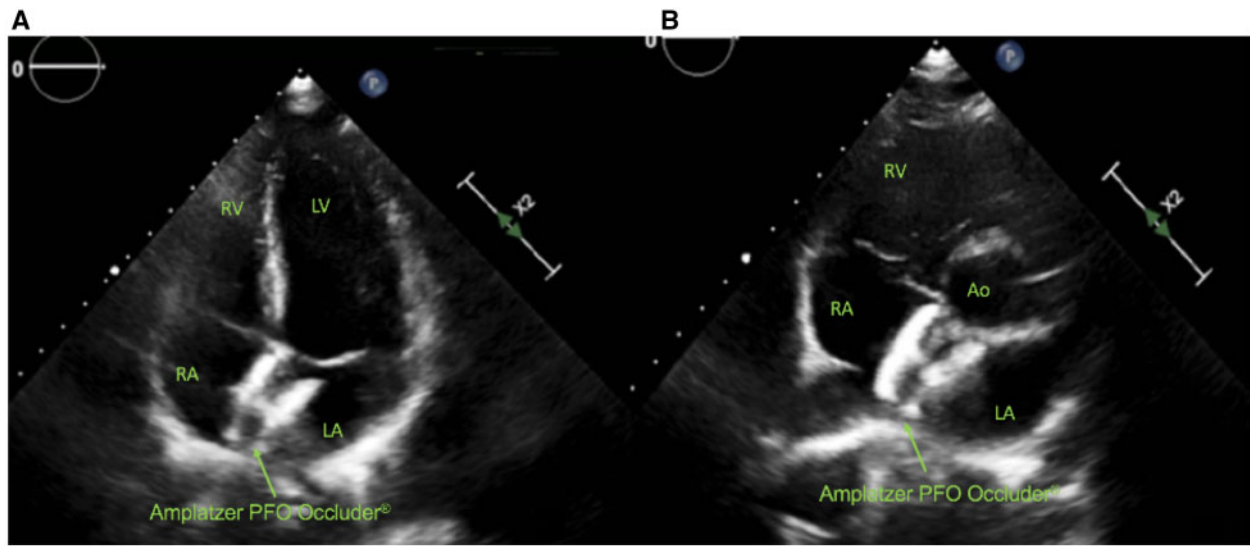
Post-procedural transthoracic echocardiography showing the 30-mm device in place. Note the close proximity of the device to the septal tricuspid valve annulus. (A) Apical four chambers view. (B) Parasternal short-axis view. Ao, aorta; green arrow, large shunt; LA, left atrium; LV, left ventricle; RA, right atrium; RV, right ventricle.
